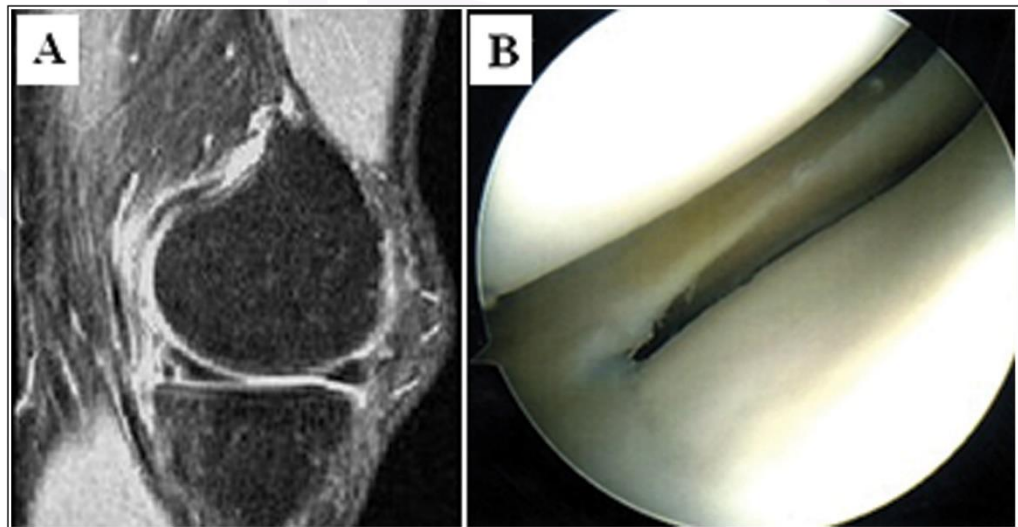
False positive MRI. Rupture of the posterior horn of the lateral meniscus on MRI (a), whereas in arthroscopy the meniscus is not damaged (b).
